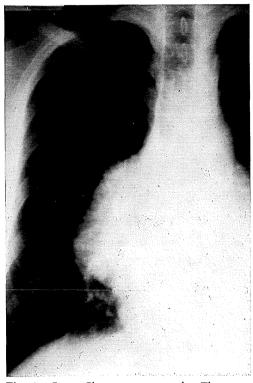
Case 1 Chest roentgenography. The tumor was located in the upper anterior mediastinum. It protruded into right thoracic cavity.
